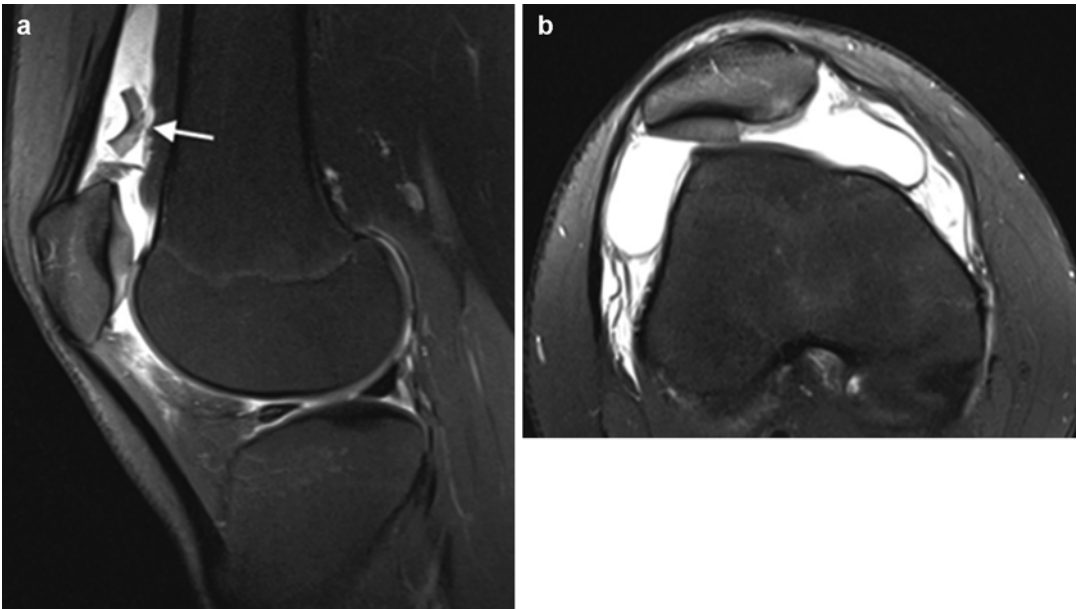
(a) Osteochondral loose bodies are identified with MRI. (b) Axial views showing an osteochondral lesion of trochlear articular cartilage
